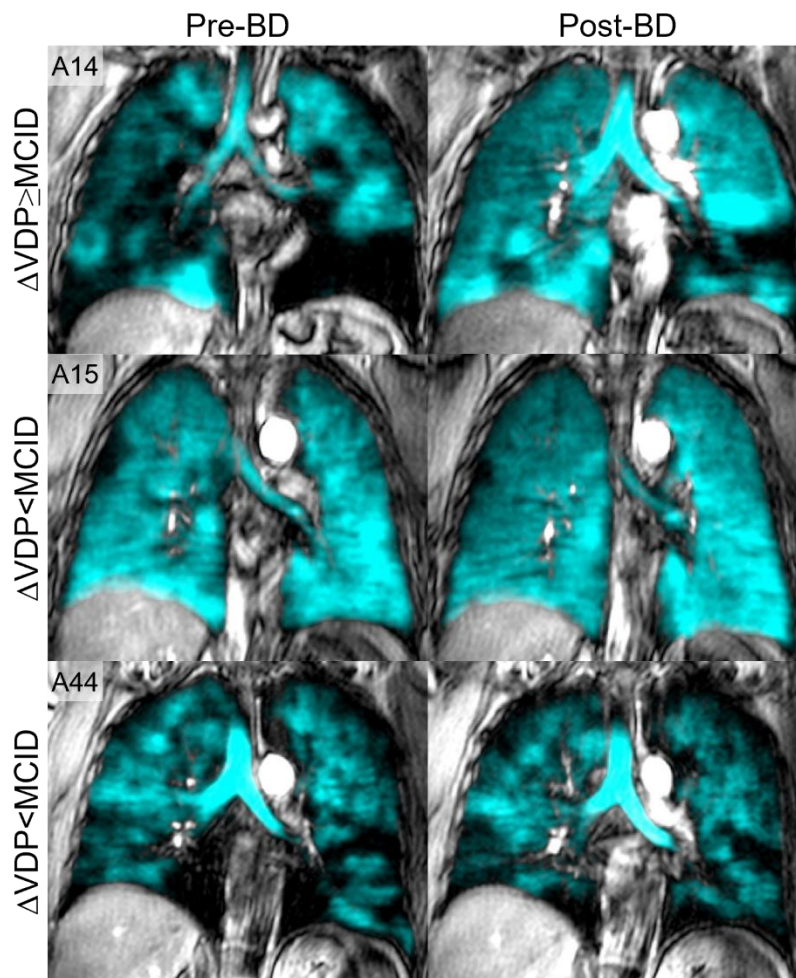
^{129}Xe MRI in participants with asthma
